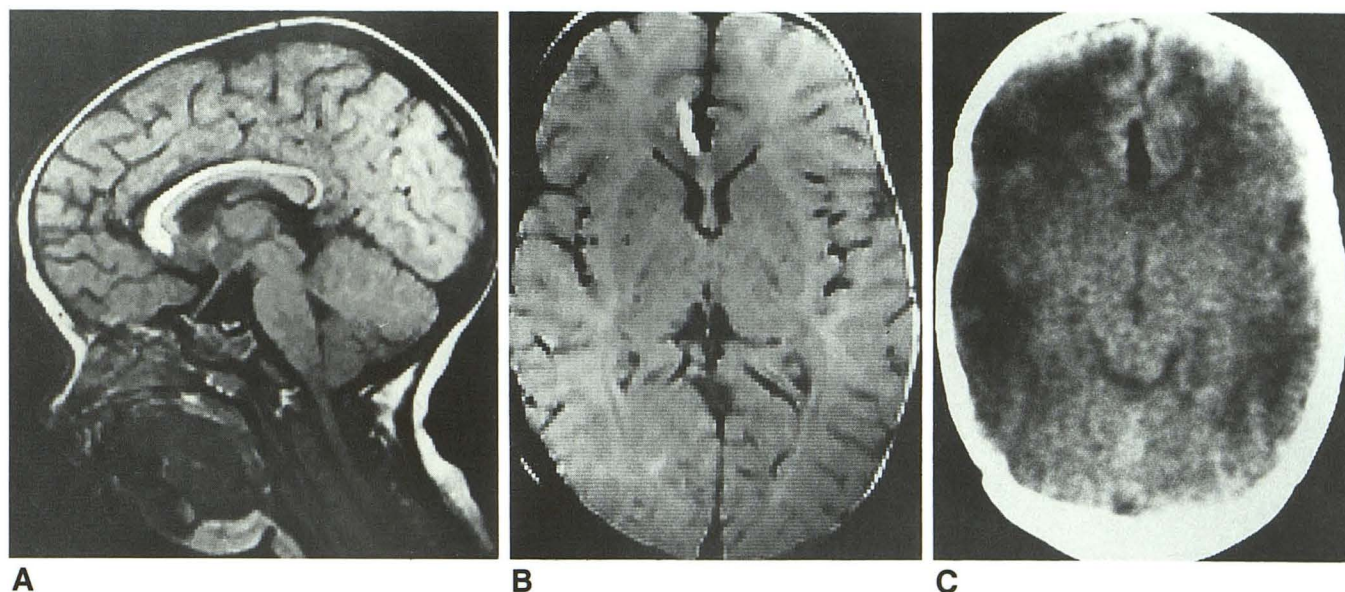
Fat signal in corpus callosum lipoma is superimposed on brain parenchyma by 3 mm, showing clinically insignificant but definite change from CT.
